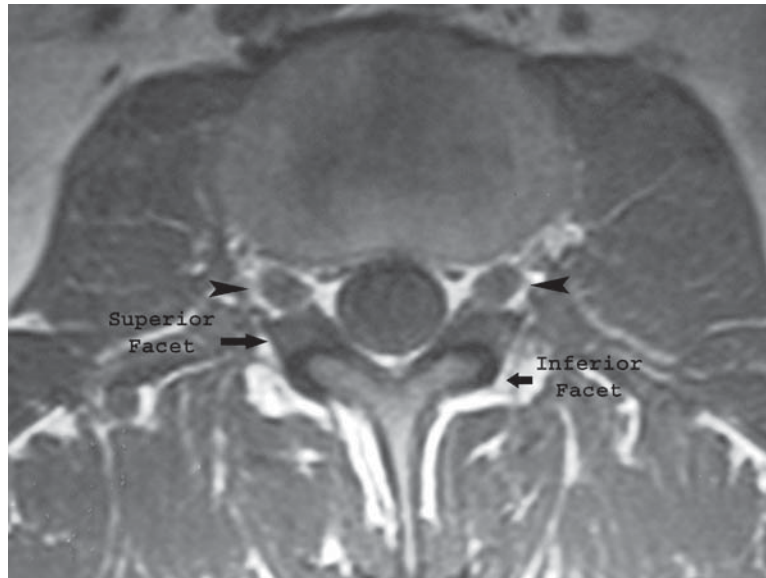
Axial T1 MRI showing the close proximity of the exiting nerve root (*arrowheads*) to the facet joint. Osteoarthritis or disc herniation can cause narrowing of the neural foramen.
